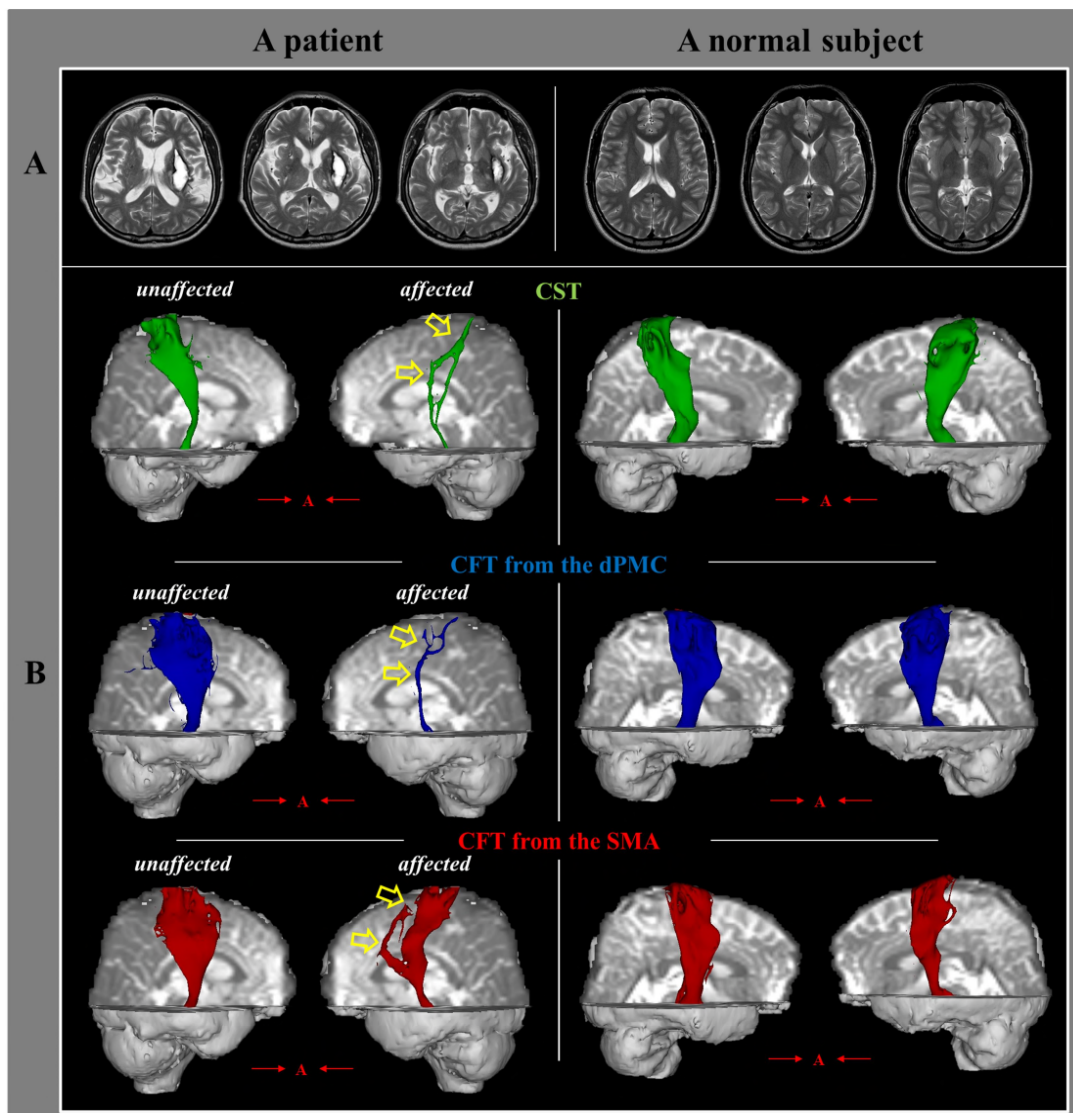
(A) T2-weighted brain magnetic resonance images of a patient (55-year-old male) and a normal subject (56-year-old male). (B) Results of diffusion tensor tractography. The corticospinal tract (CST, green color) and the corticofugal tracts (CFTs) from the dorsal premotor cortex (dPMC, blue color) and supplementary motor area (SMA, red color) are reconstructed in both hemispheres. Injured neural tracts are indicated with yellow arrows.
